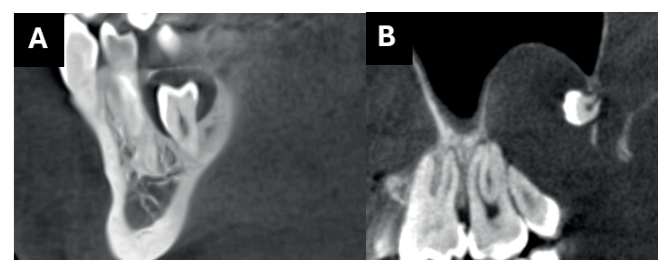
Representative CBCT images of ST-related cystic formations A. Cystic formation in the mandibular premolar region in the sagittal section B. Cystic formation in the maxillary molar region in the sagittal section.
